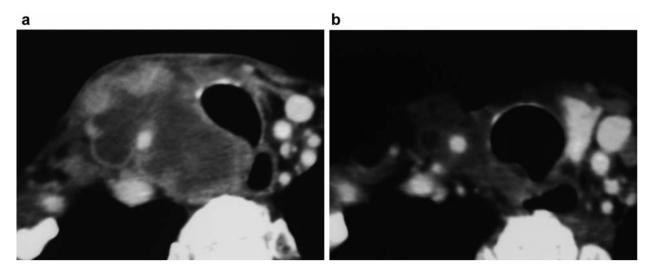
A responder to chemoradiotherapy (CRT). Computed tomography of a 74-year-old male patient, before (A) and after (B) CRT are shown. The therapeutic effect was judged as complete response, and the effect lasted until the patient died of cachexia. The patient survived for 188 days from the initial diagnosis of anaplastic thyroid cancer with stable local control.
